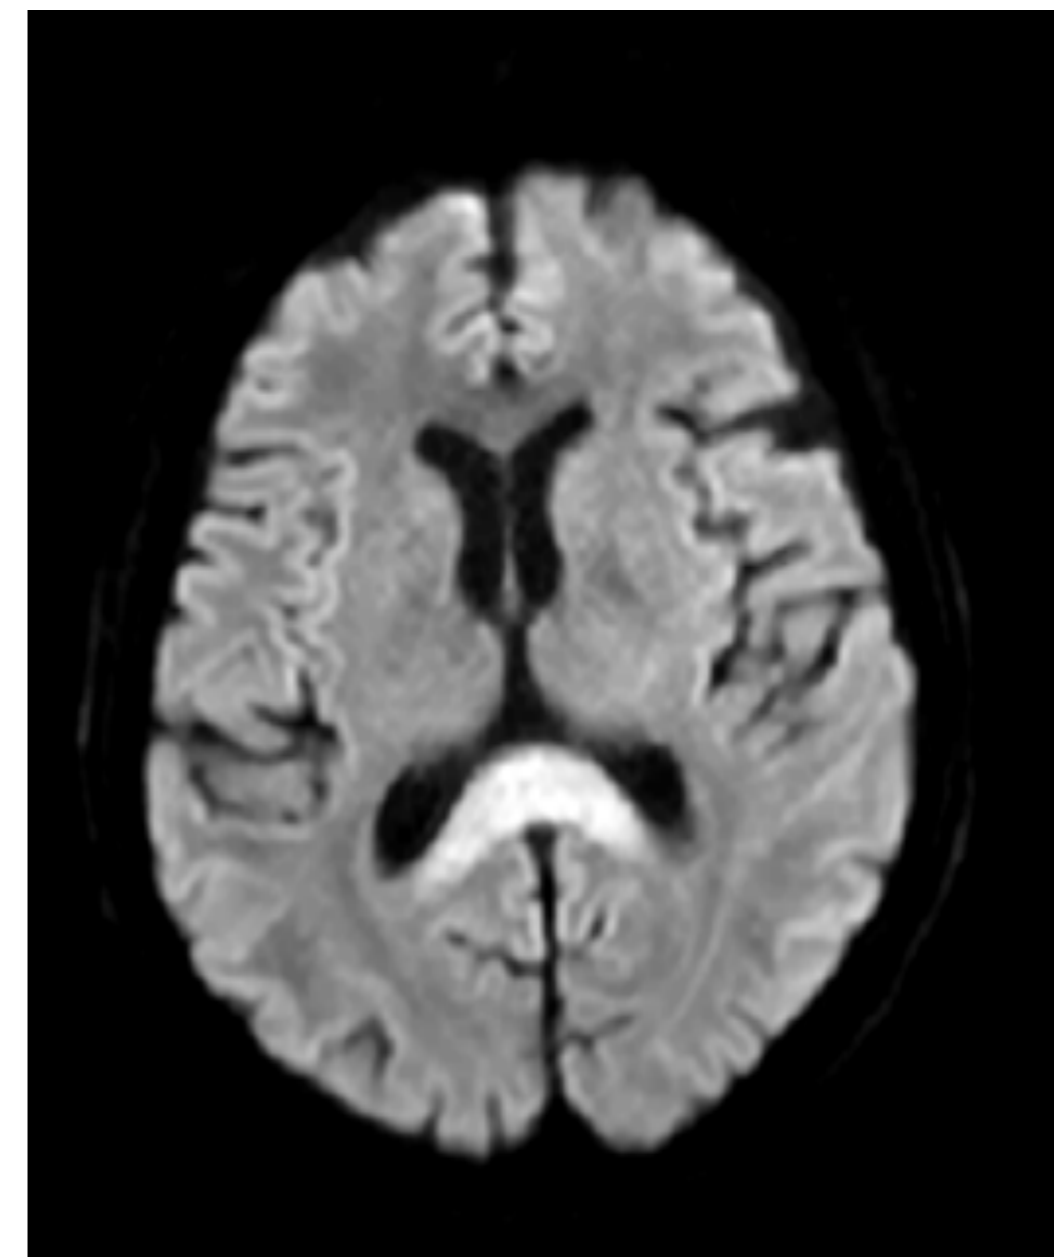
DWI show hyperintensity of the corpus callosum; fig. 2: ADC images show a corresponding less prominent hypointensity in the splenium.
